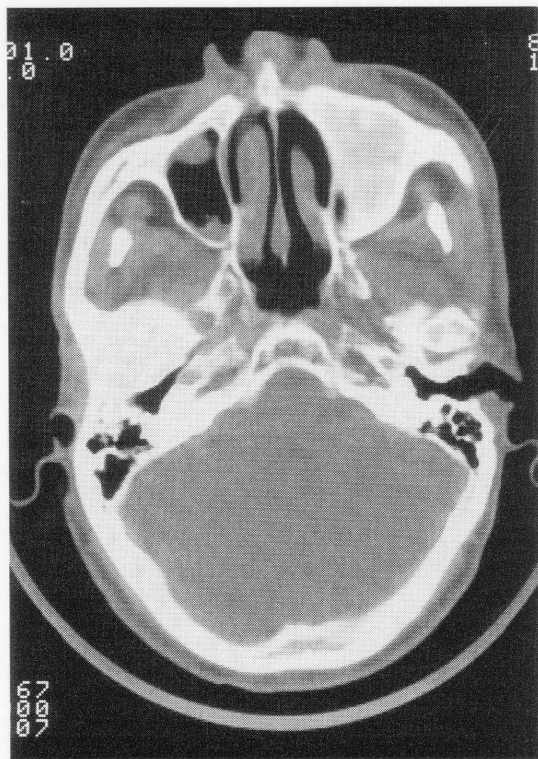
Case 2. CT of the skull showed sclerosis and hyperplasia of the left facial bone with no periosteal reaction.
